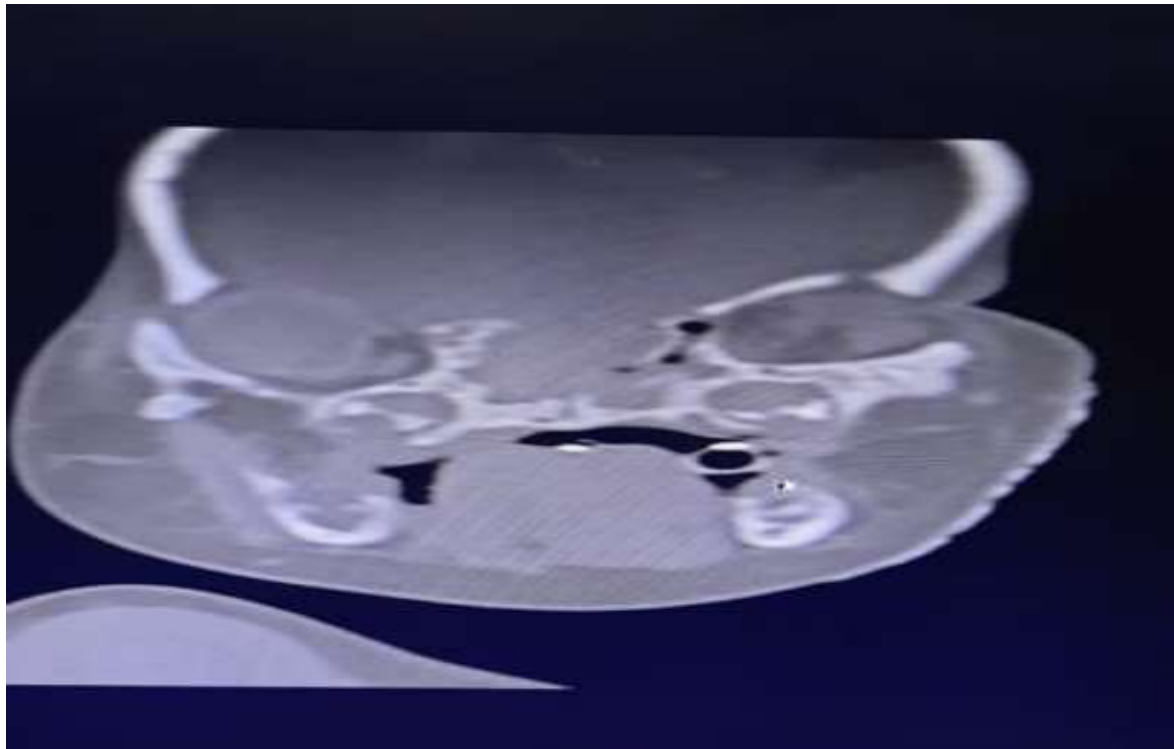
CT image showing hypoplastic sinuses ,absent eyeball
